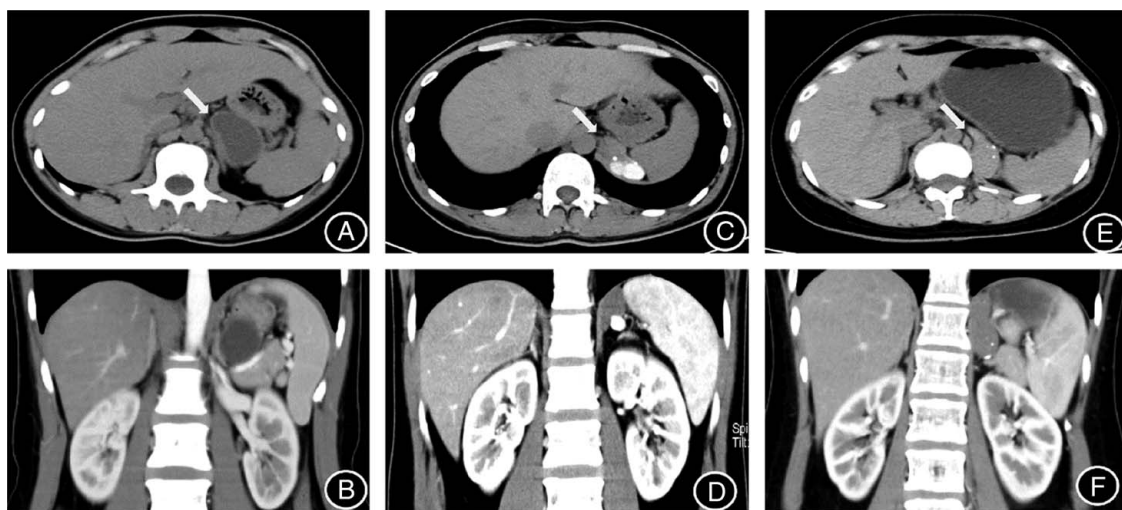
Abdominal contrast-enhanced computed tomography scans of the lesions in the left retroperitoneal region (white arrows). (A and B) An ovoid thick-walled cystic lesion without calcification and enhancement in case 1. (C and D) A fusiform solid lesion with massive calcification in case 2. (E and F) An ovoid solid lesion with punctate calcification in case 3.
